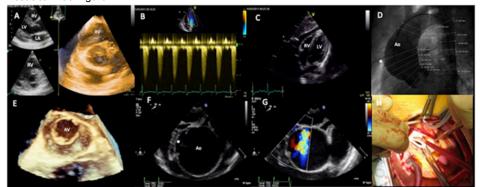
Panel A: a transthoracic 3 D single beat acquisition and 3 D rendering of the unicuspid aortic valve. Panel B: a Continuous Wave Doppler on the Aortic valve shows increased gradients. Panel C: a subcostal transthoracic view, white arrow points at the mild pericardial effusion. Panel D: aortography showing a dilatation of ascending aorta. Panel E: a transesophageal 3D rendering of the unicuspid aortic valve. Panel F and G: transesophageal aortic views of the aortic dissection. Panel H: unicuspid aortic valve surgery view.
